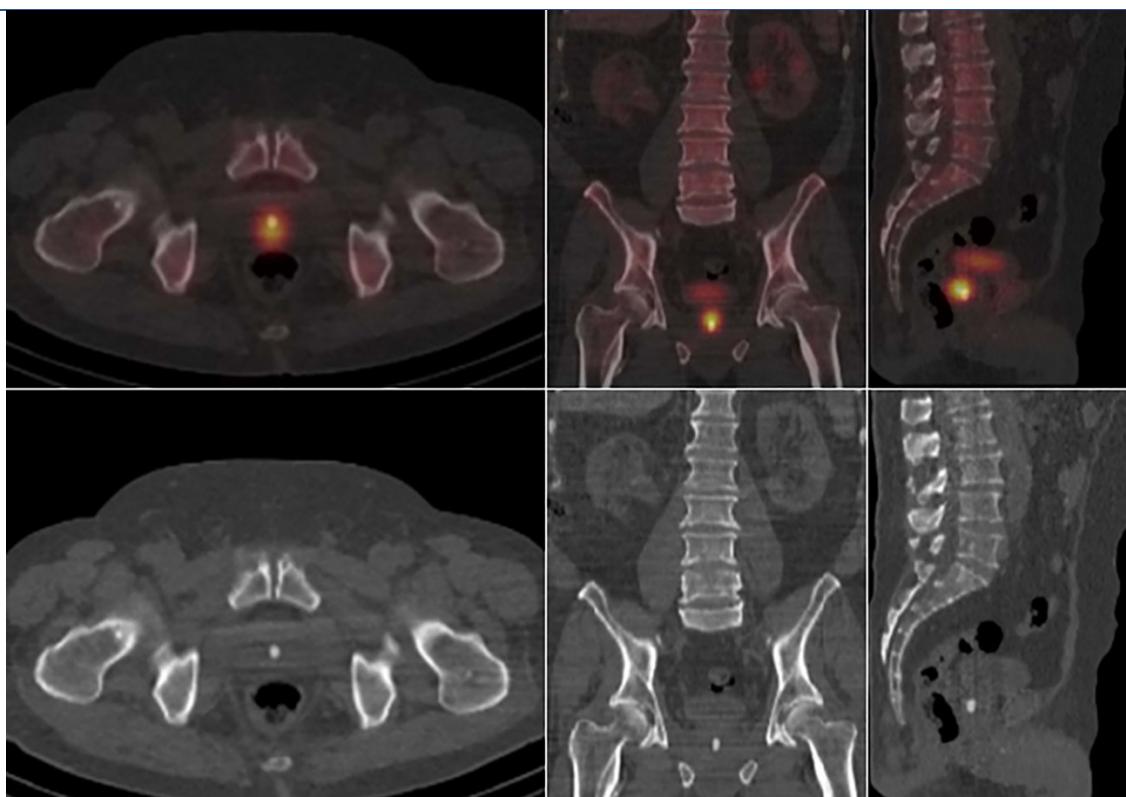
Trans-axial, coronal, and sagittal hybrid SPECT/CT imaging have successfully localized the observed radiotracer activity to the prostate gland. Corresponding low-dose CT images revealed a focal calcification at the site of increased radiotracer uptake, positioned along the midline of the prostate, which may resemble primary calcified prostate cancer
